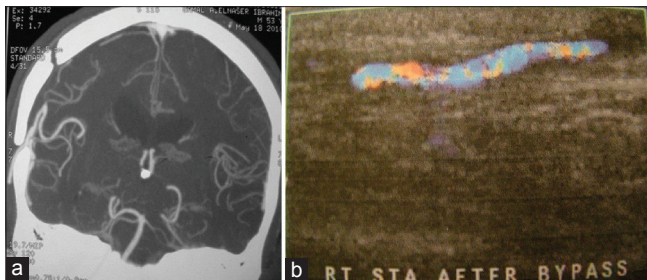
(a) Postoperative computed tomography angiography revealing a patent by-pass graft with improvement of blood flow in the middle cerebral artery (MCA) territory in comparison to the contralateral side, (b) transcranial colored duplex revealing the same findings with improvement of flow velocity has compared to the contralateral normal MCA
